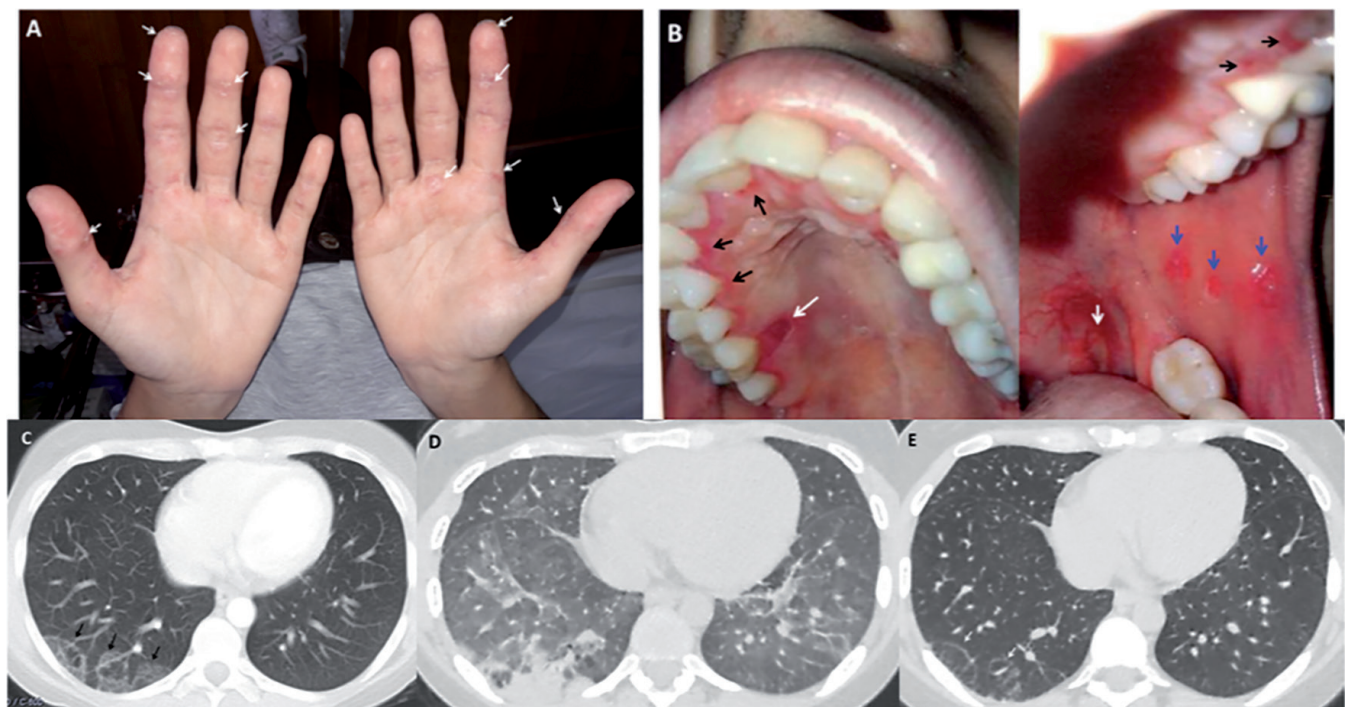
(A) Palmar skin at presentation: hyperkeratotic eruptions with desquamation and rhagades mainly on the tips and sides of the fingers (arrows). Oedematous proximal interphalangeal joints (2nd, 3rd) due to arthritis can be noted on both hands. (B) Painful oral ulcers of the buccal mucosa and the hard palate (deep ulcers: white arrows, superficial ulcers: blue arrows) and marginal erythematous gingivitis (black arrows). (C) Chest high resolution CT (lung windows, level of lung bases) at presentation: ground glass opacities are noted peripherally in the right lung base (arrows) with associated interstitial thickening. (D) Chest high resolution CT with symptoms of fever, rapidly progressing shortness of breath, tachypnea, tachycardia and hypoxia. Extensive bilateral ground glass opacities are noted in the mid and lower lung zones. Peripheral consolidation in the right lung base and peribronchial consolidation in the left lower lung lobe are seen, without traction bronchiectasis or interlobular septal thickening. (E) Chest high resolution CT four months after initiation of combination immunosuppressive therapy. Complete regression of the ground glass opacities and consolidations is evident. There remains interstitial thickening and fibrotic changes peripherally in the right lung base.
